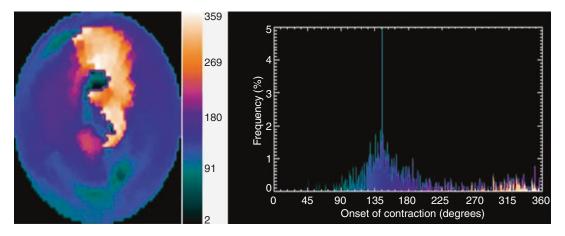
Assessment of LV dyssynchrony with gated myocardial perfusion SPECT. Example of a heart failure patient with LV dyssynchrony as assessed with gated
